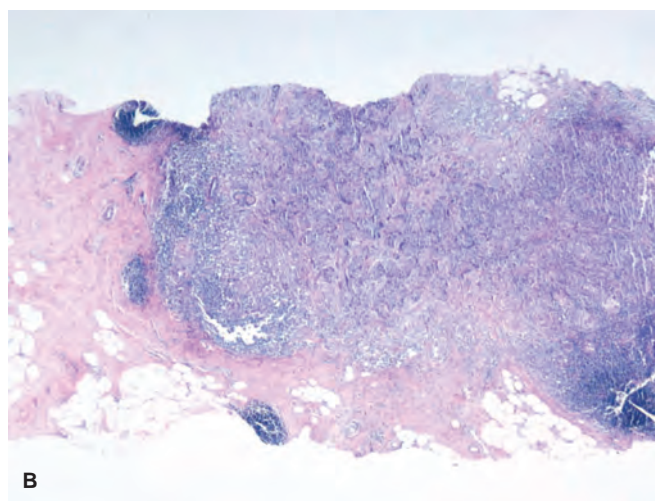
Magnetic resonance imaging (MRI)-guided core biopsy. (A) Sagittal MRI of a 30-year-old *BRCA1* positive with a 6-mm peripherally enhancing lesion with irregular borders (*arrow*). (B, C) Pathology reveals a high-grade invasive ductal carcinoma.
